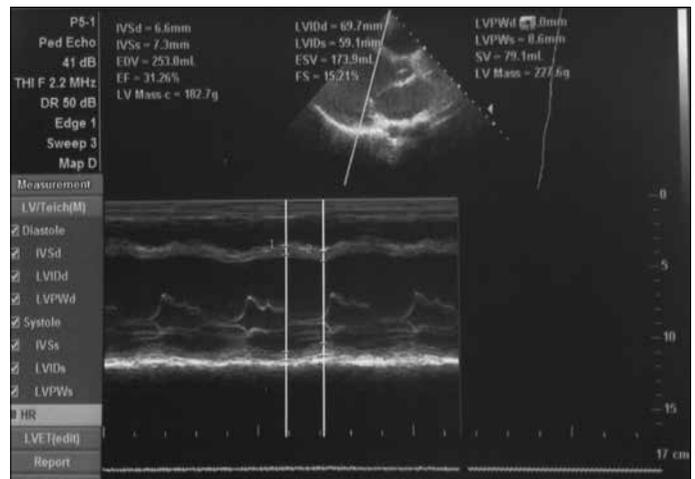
M-mode echocardiogram showing dilated left ventricle and decreased left ventricular contractility.
